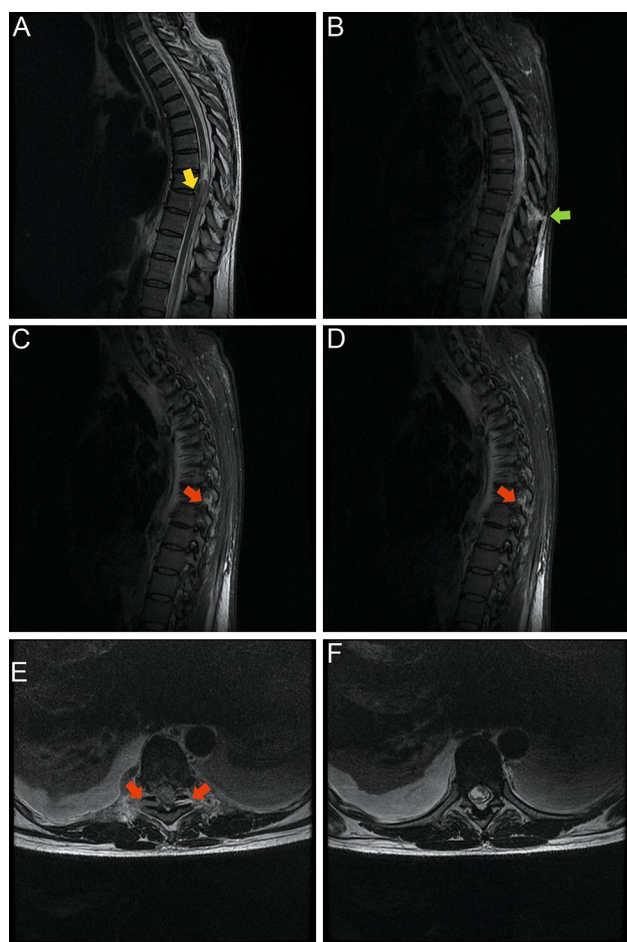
MRI of the thoracic spine. Sagittal T2-weighted (a) and sagittal STIR (b) images noticed rupture of the posterior longitudinal ligament and the posterior ligamentous complex (PLC), respectively. T8–T9 anterolisthesis not present in the previous CT was also described. Left sagittal (c), right sagittal (d) and axial (e) STIR images depicted bilateral facet joint capsules damage. f Axial T2-weighted images confirmed that the spinal cord was almost completely interrupted except in the left side. In a signal hyperintensity suggested edema in the upper and lower spinal cord
